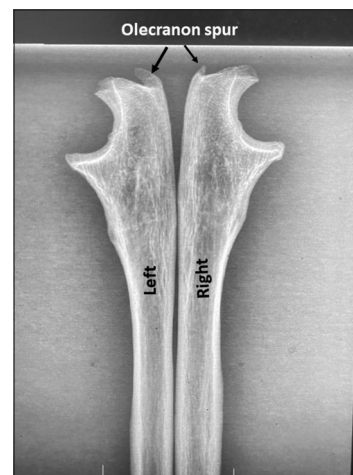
Plain radiograph of the ulnae showing olecranon spur
